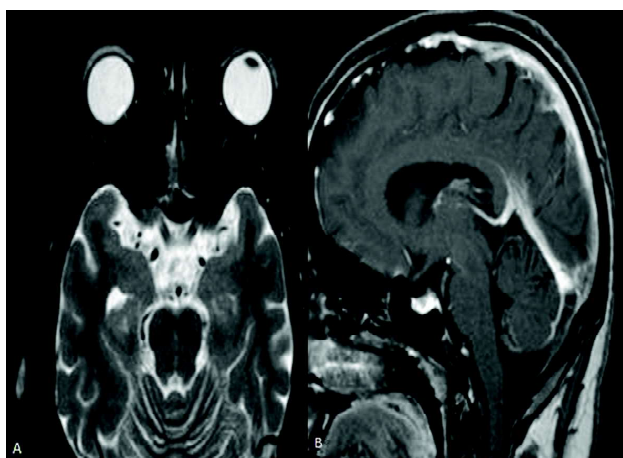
Repeat MRI after treatment shows no abnormal distension of the perioptic subarachnoid space with normal contour of the posterior sclera (A) with return of the normal height and size of the pituitary gland (B).
